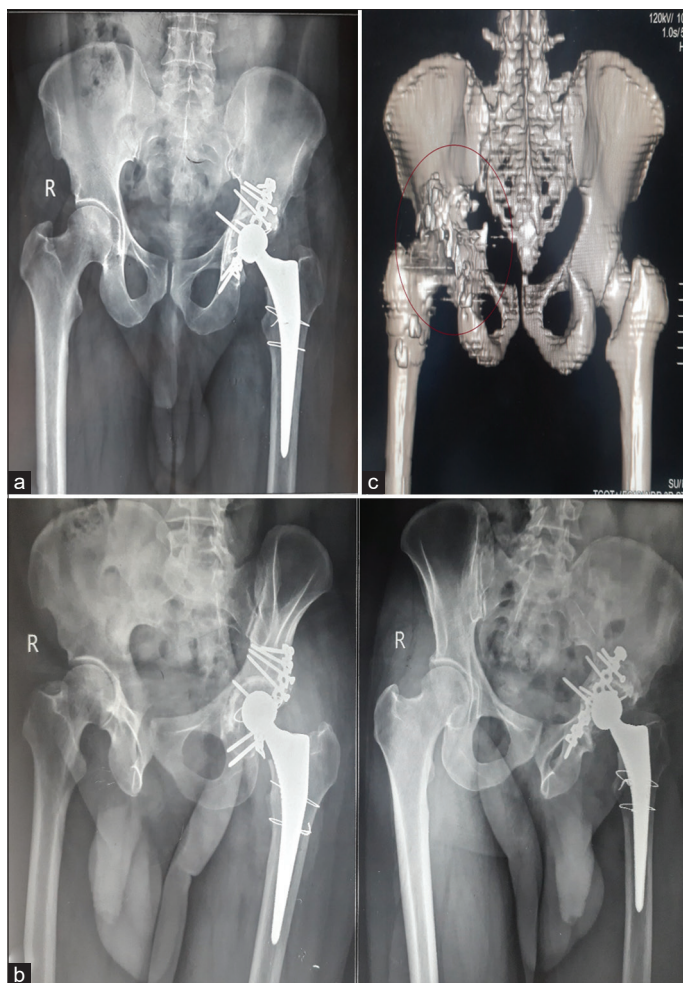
On 1-year follow-up. (a) X-ray anteroposterior view; (b) X-ray obturator oblique and iliac oblique views; and (c) 3D computed tomography image showing good incorporation of graft and adequate posterior coverage for the acetabular cup
